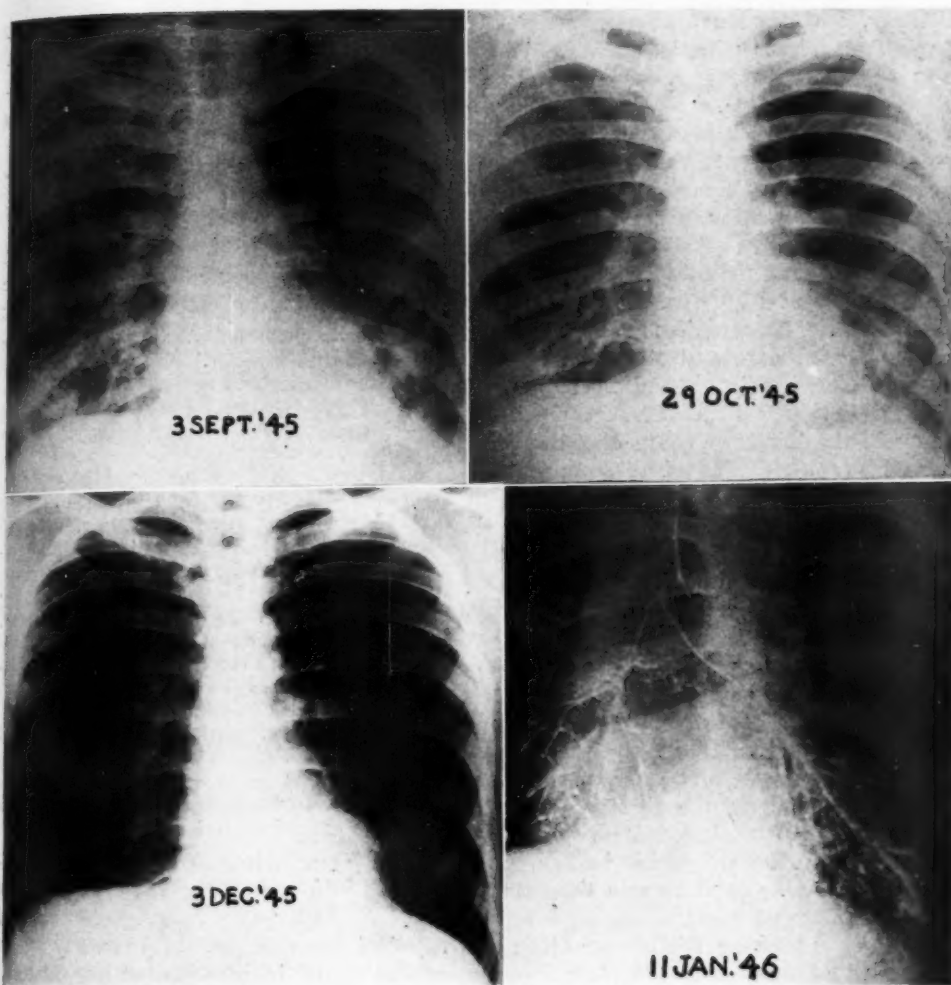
Case 5: Successive roentgenograms (Sept. 3, Oct. 29, Dec. 3, 1945) of a patient with primary atypical pneumonia and subsequent development of bronchiectasis as shown by bronchography (Jan. 11, 1946).
